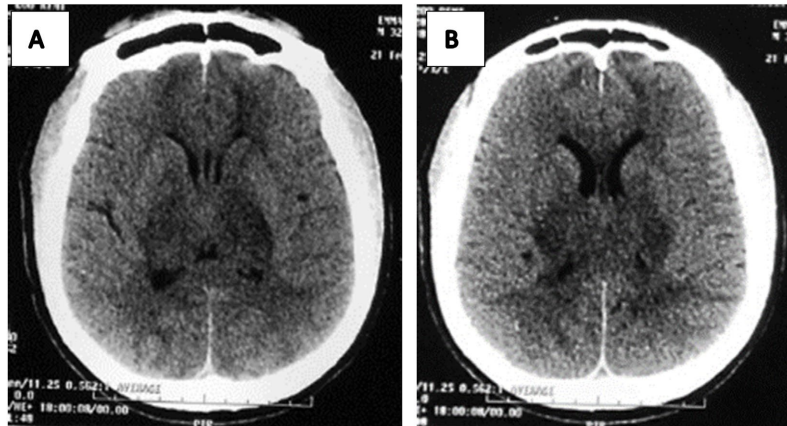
Brain CT at 24 hours showing bilateral, diffuse capsulo-thalamic hypodensities (A, B) with an oedematous appearance.
